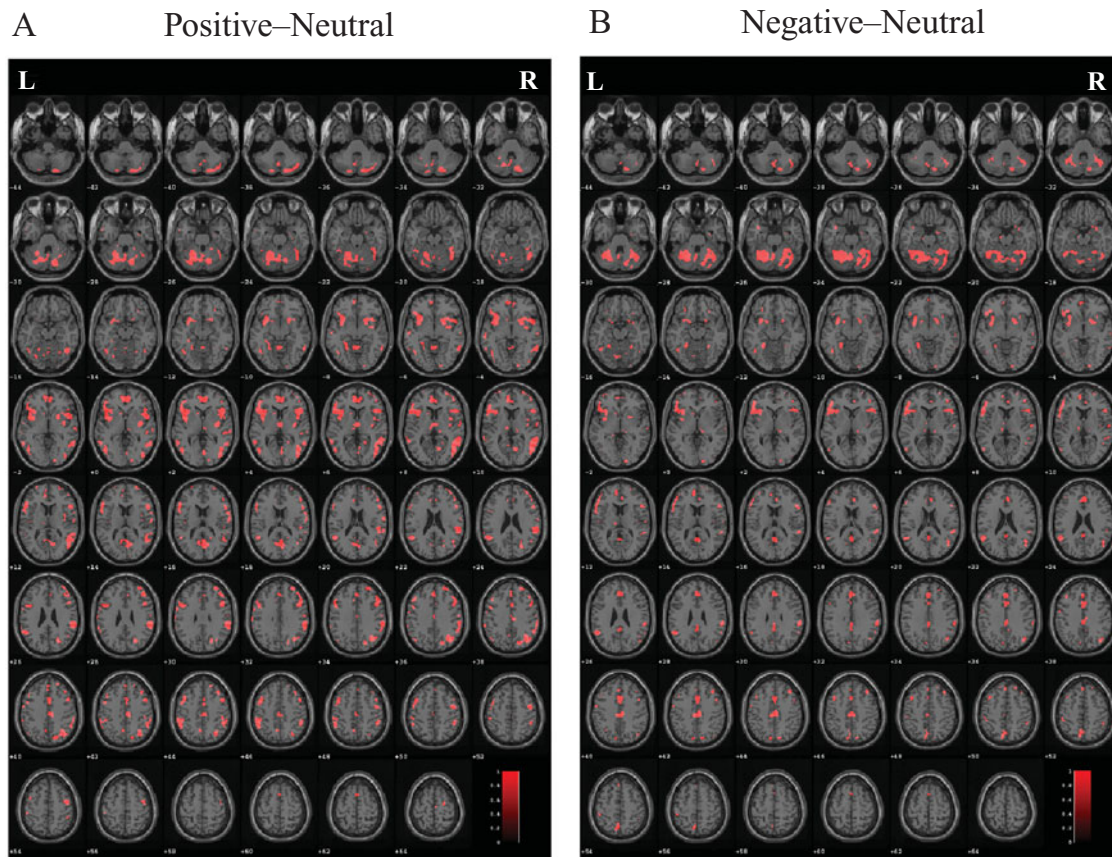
Variance maps based on positive–neutral (A) and negative–neutral (B) contrasts. Both maps were overlaid onto a standardized structural T1-weighted MRI template with axial orientation in each contrast. Axial images are representative slices displayed in 2-mm increments along the  $z$ -axis ( $z = -44$  to  $64$ ). Regions of variance are indicated in red. L indicates left hemisphere, and R indicates right hemisphere.
